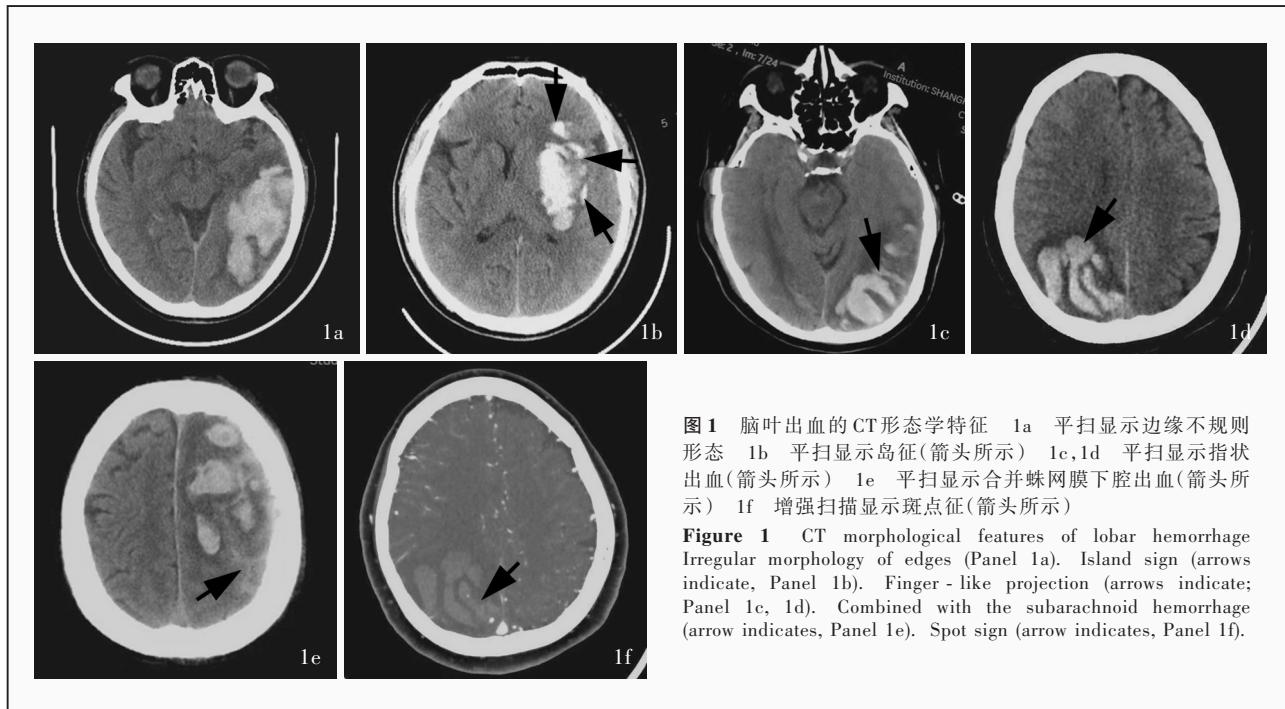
脑叶出血的 CT 形态学特征 1a 平扫显示边缘不规则形态 1b 平扫显示岛征(箭头所示) 1c,1d 平扫显示指状出血(箭头所示) 1e 平扫显示合并蛛网膜下腔出血(箭头所示) 1f 增强扫描显示斑点征(箭头所示)
